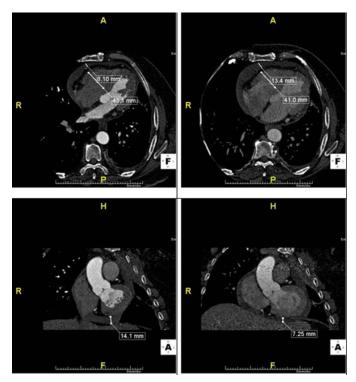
Cardiac CT demonstrates redistribution of pericardial effusion in diastole during inspiratory and expiratory breath holding. Antero-lateral pericardial effusion (at the level of RV free wall on axial views in top panel) measures 8.1 mm during inspiration (Figure 3a, upper panel) and 13.4 mm during expiration (Figure 3b, upper panel). Inferior pericardial effusion (adjacent to the RV and LV inferior wall on coronal views in bottom panel) measuring 14.1 mm during inspiration (Figure 3a, lower panel) and 7.25 mm during expiration (Figure 3b, lower panel). RV diastolic diameters show 43.1mm during inspiration (Figure 3a, upper panel) and 41.0 mm during expiration (Figure 3b, upper panel).
